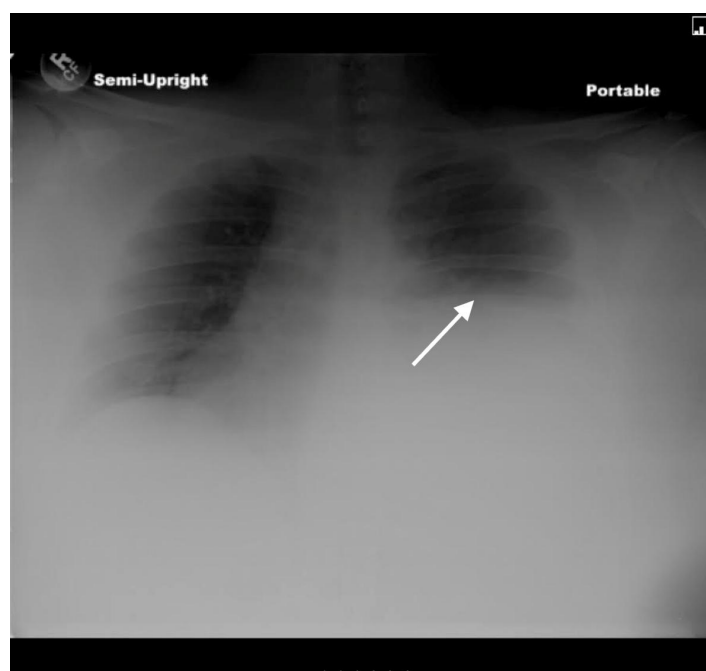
Anteroposterior chest radiograph demonstrating elevation of left hemidiaphragm (arrow).
